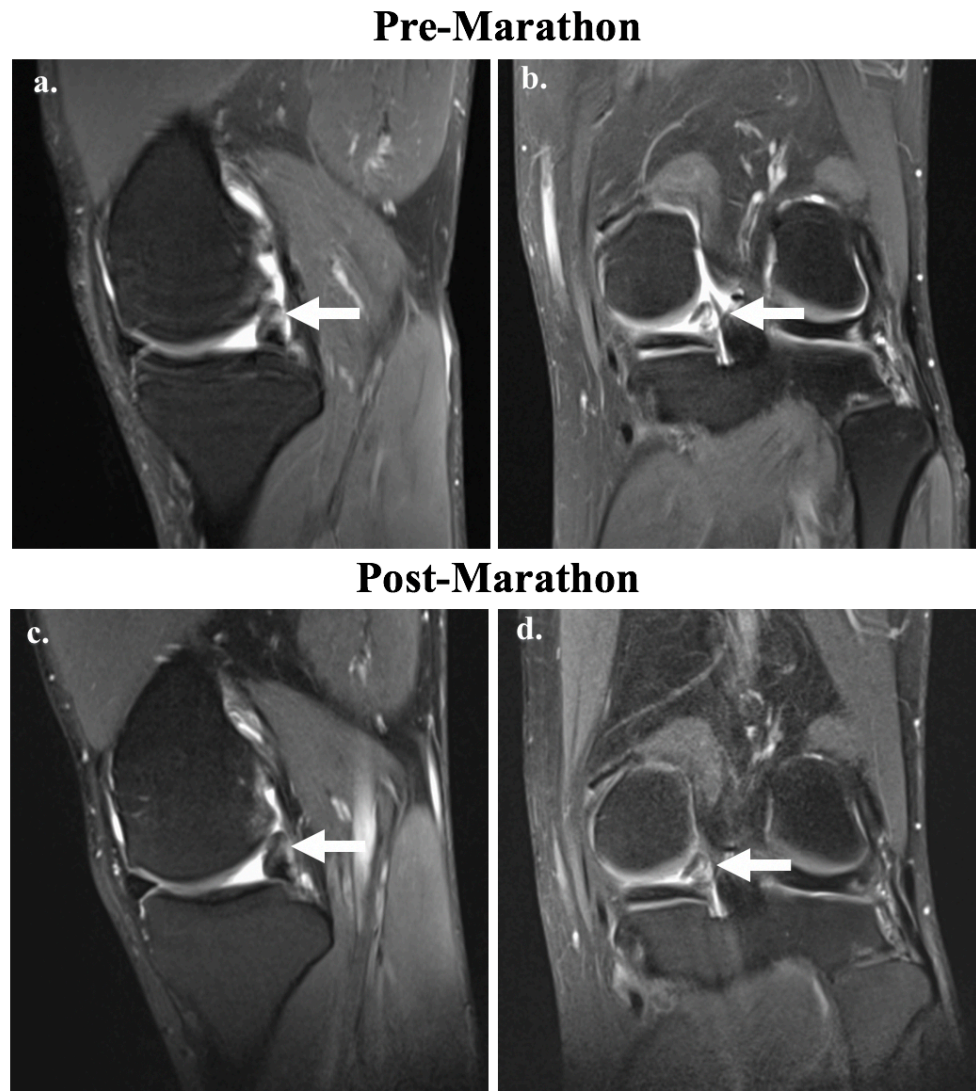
MRI scans of a 45 year old marathon runner with finishing time 3 hours and 51 min who was diagnosed during the pre-training period with bucket-handle tear of the posterior horn of the medial meniscus as it is indicated by (a) the sagittal proton-density fat-saturated image (white arrow) and the (b) coronal image where the meniscal flap within the intercondylar notch (arrow) is shown. The status of the meniscal tear did not change in 2 weeks after the marathon (see c, d).
